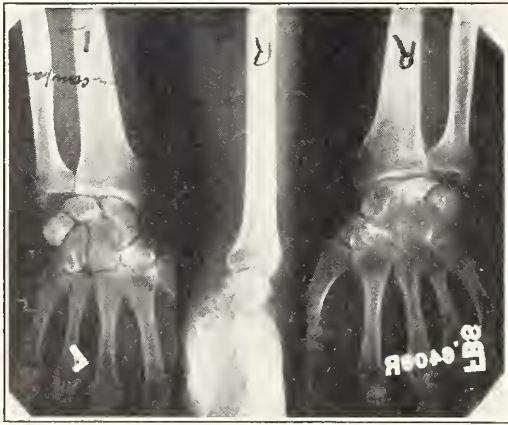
Roentgenogram (right) showing an osteoporosis as well as a sclerosis of the semilunar. Normal (left), for comparison.
